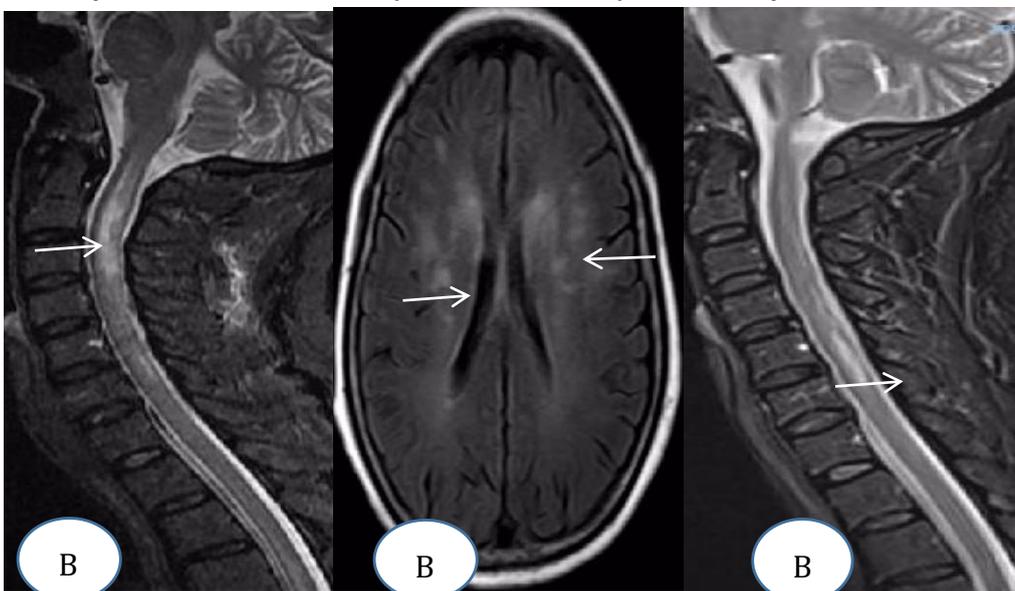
Figure B (the early-onset patient): B1, PatchySTIR highsignal in cervical spinal cord (December 2021). B2,Dotted FLAIR highsignal in head (December 2021). B3,Long stripSTIR highsignal in cervical spinal cord (October 2021).
